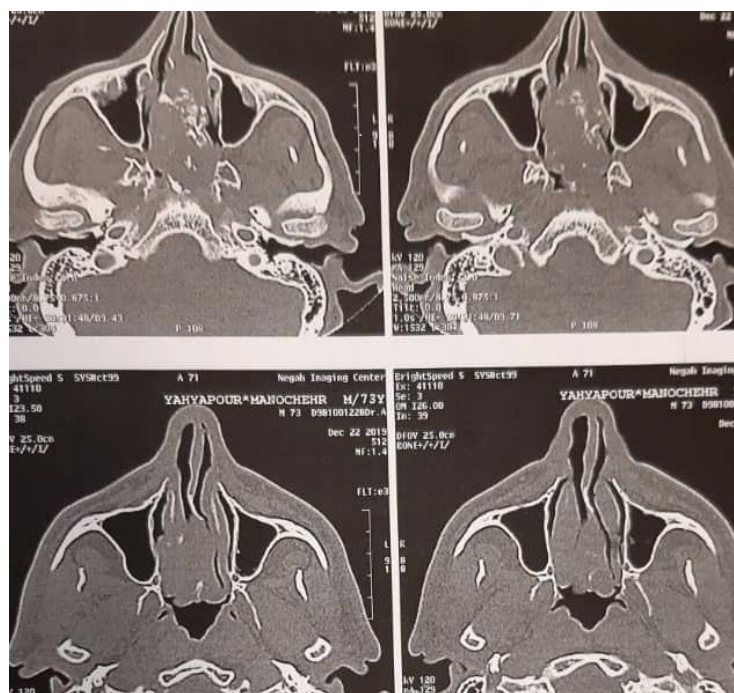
Chondrosarcoma CT-scan of nasal cavity with axial cut
